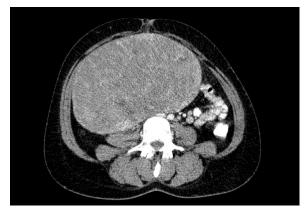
Abdominopelvic CT scan
